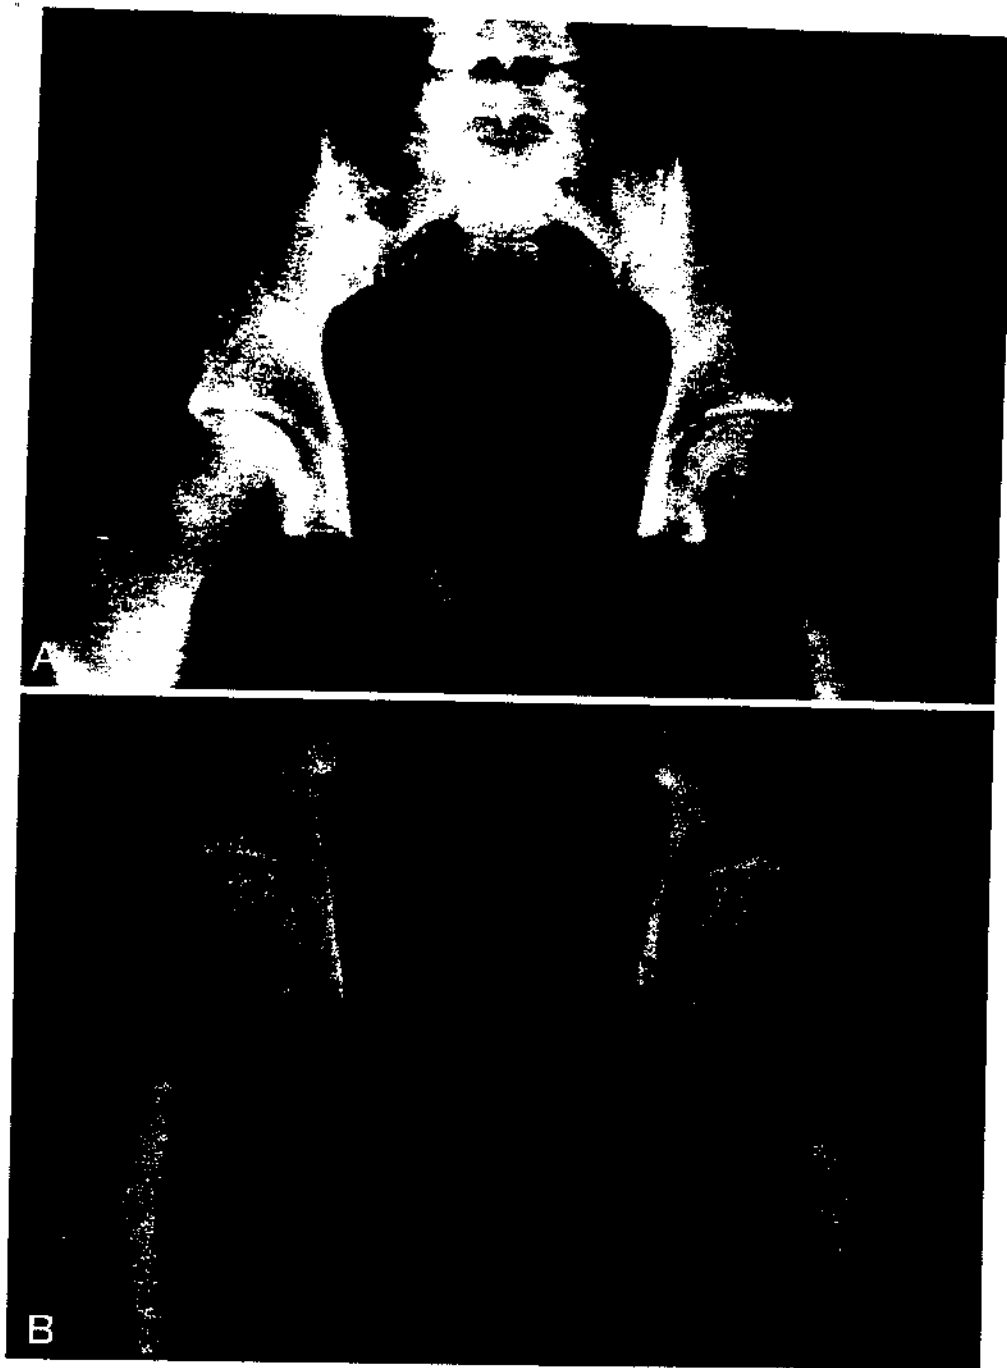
A) AP pelvis radiograph at 3 wk after presentation demonstrating erosion in the left superior pubis. B) AP pelvis radiograph demonstrating new bone formation in this region at 3-month follow-up.
